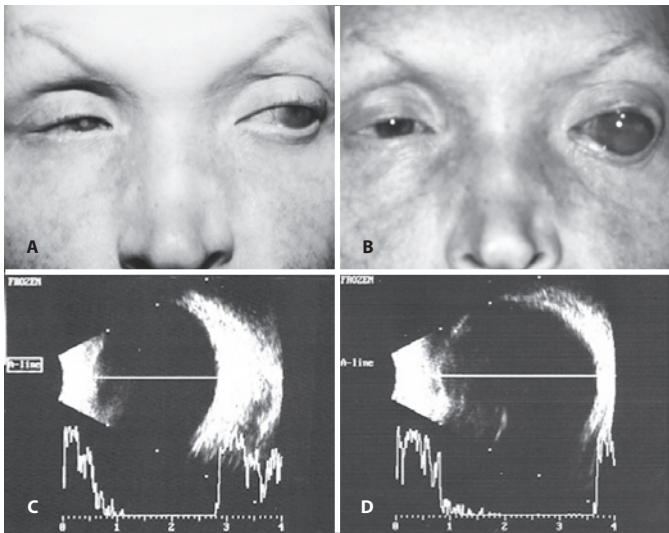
A) External appearance at first examination, loss of eye brow and lashes, depressed nasal bridge, epithelial corneal defect in the right eye and buphthalmos at left. B) External appearance after 6 years, showing the progression of the buphthalmos of the left globe. C and D) A-scan ultrasound images of both eyes showing an axial length of approximately 25 mm of the right eye and more than 36 mm of the left.
